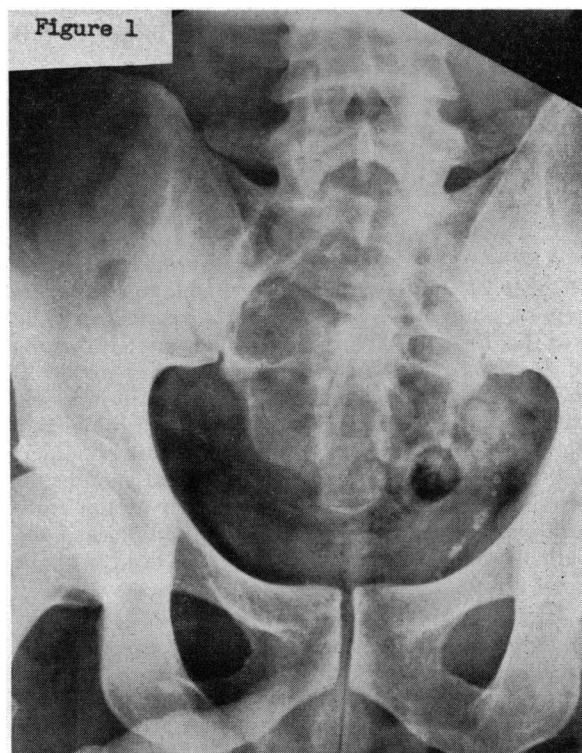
Preoperative roentgenogram showing destruction of sacrum.
